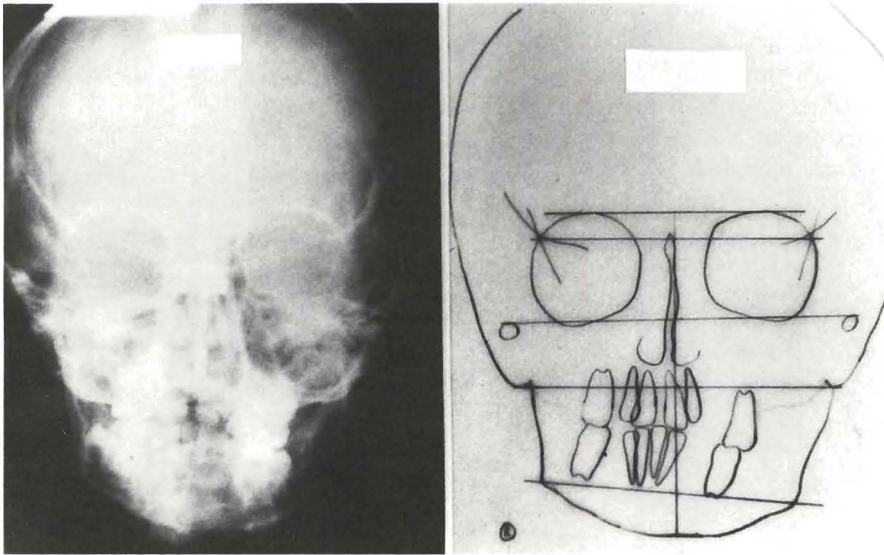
PA radiograph and tracing demonstrating overdevelopment of the left mandibular corpus and gonial angle, increased vertical dimensions, and asymmetrical sphenoid and mastoid planes.
